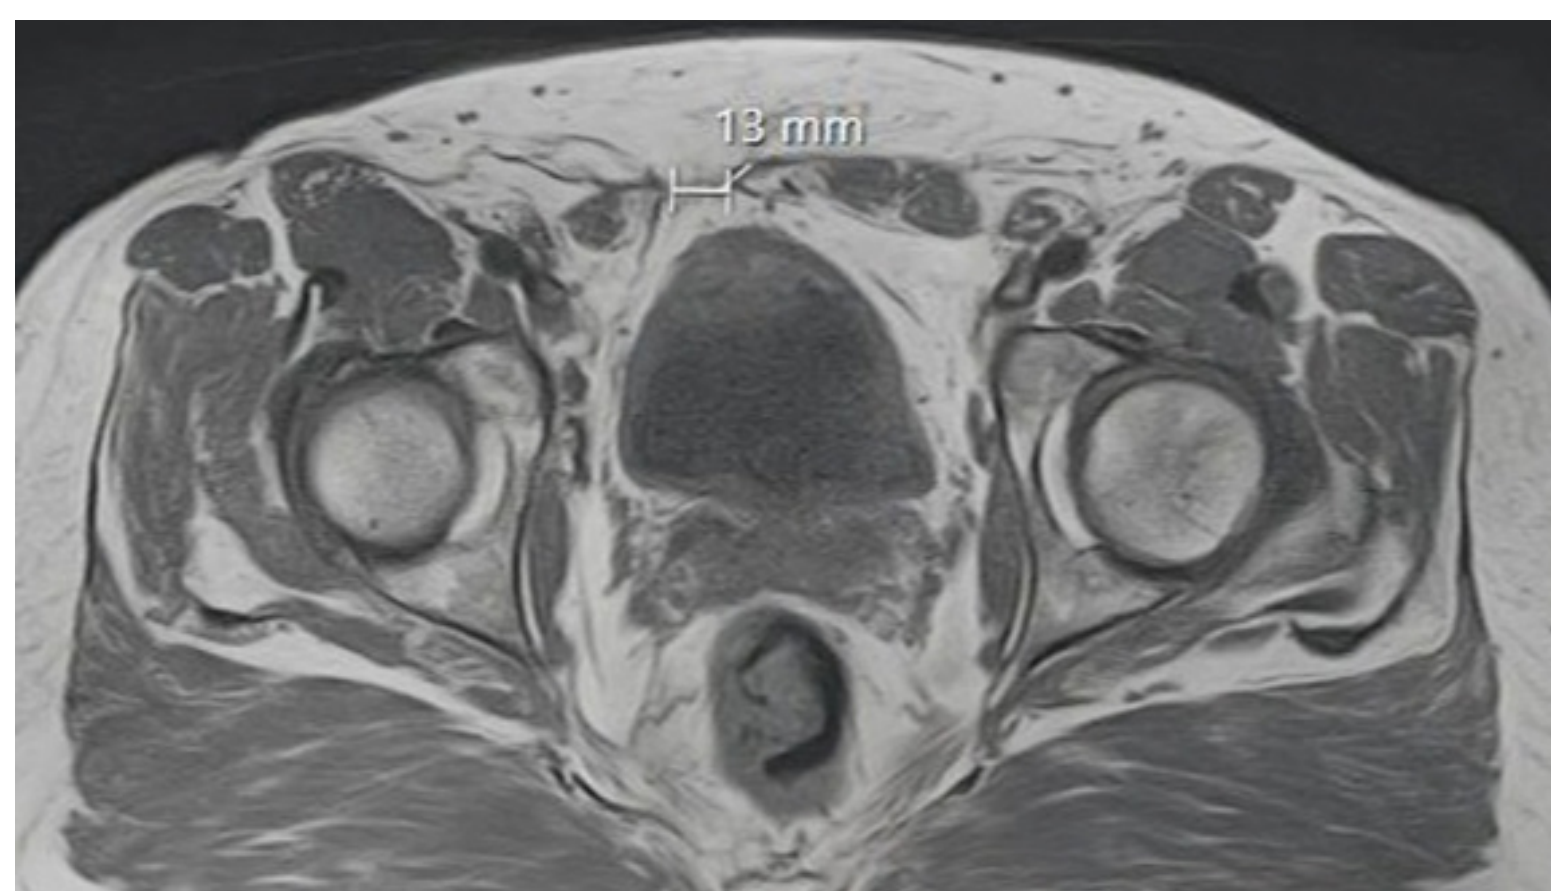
MRI right inguinal hernia Patient A
